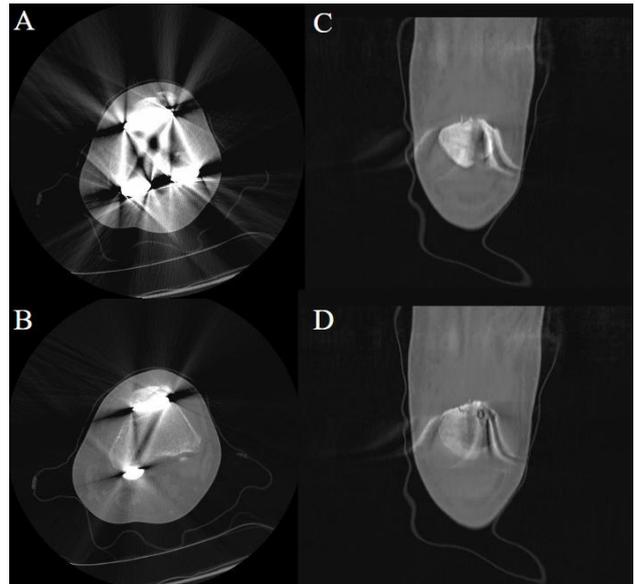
(A, B) Axial and (C, D) coronal computed tomography obtained at seven months post-operatively after total knee arthroplasty.
